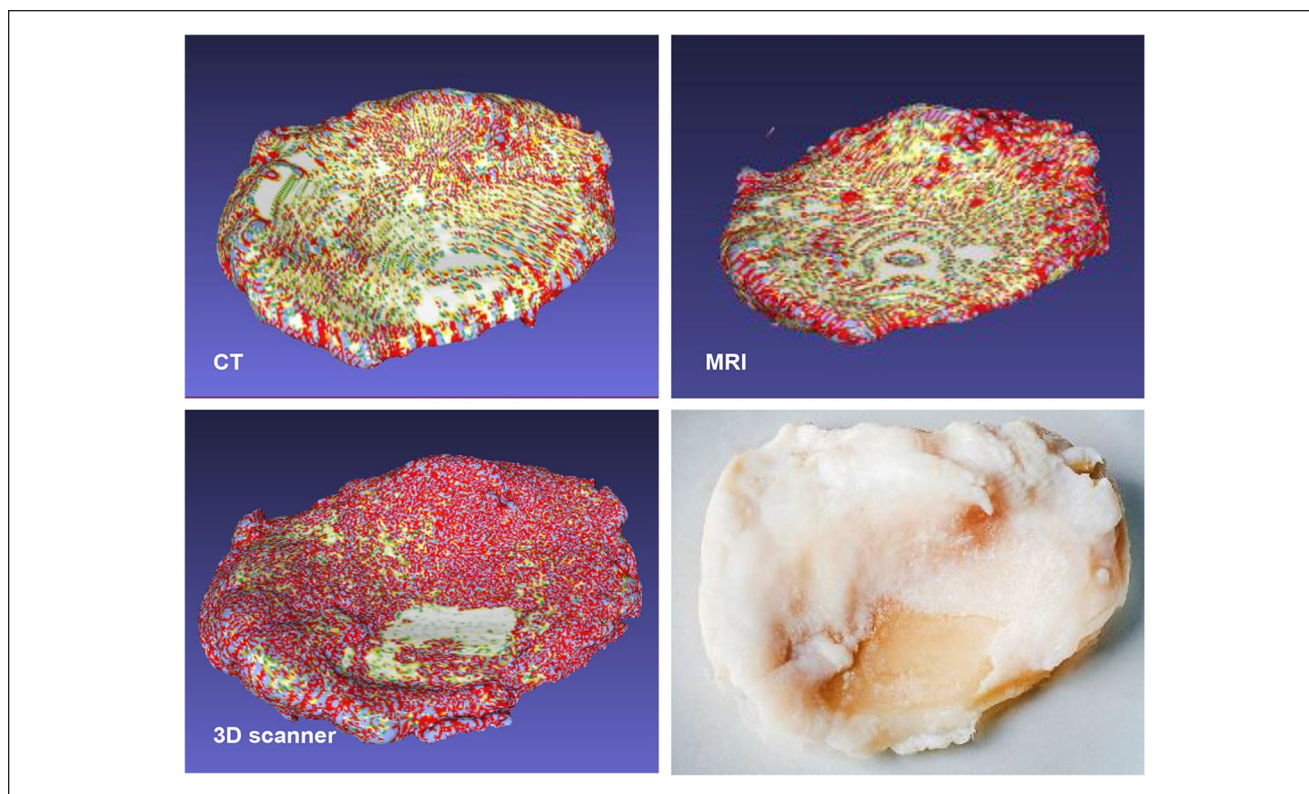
Gaussian curvature analysis of 3D models of the tibial plateau generated from scanning (A) computed tomography (CT), (B) magnetic resonance imaging (MRI), and (C) 3D scanning of (D) the tibial plateau. Red color indicates a positive Gaussian curvature, blue color indicates a negative Gaussian curvature and green color indicates that the Gaussian curvature approaches zero.
